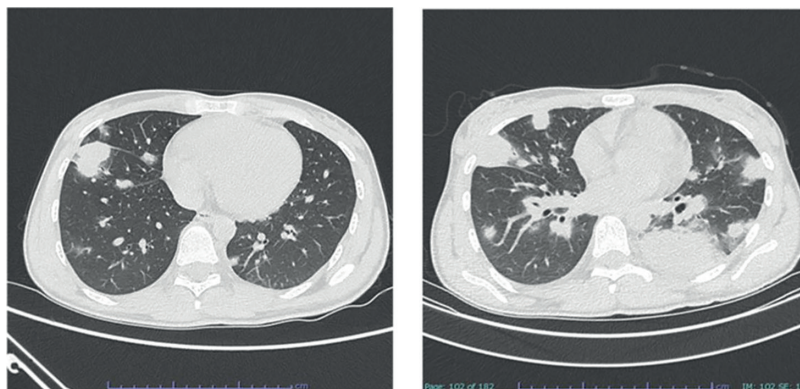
Chest CT: Showing subpleural round consolidations with features of cavitation. Follow-up CT after three days revealed rapid expansion in both size and number of consolidations.
